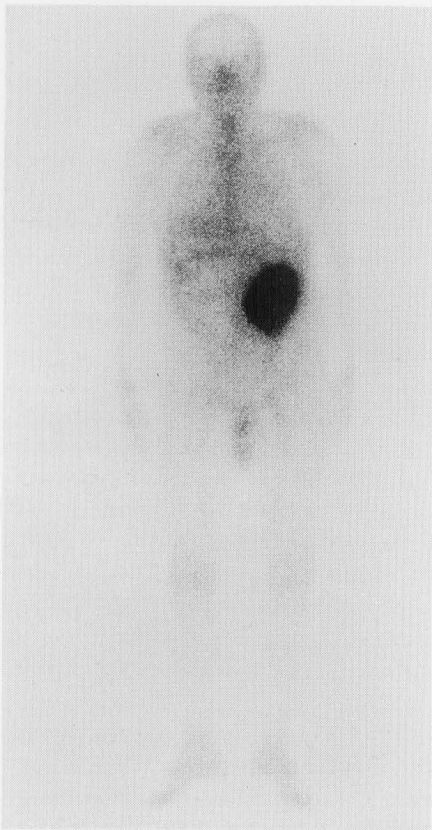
An anterior whole-body ^{67}Ga scintigraphy demonstrates an intense uptake which may correspond to the left renal large mass disclosed on CT scan.
